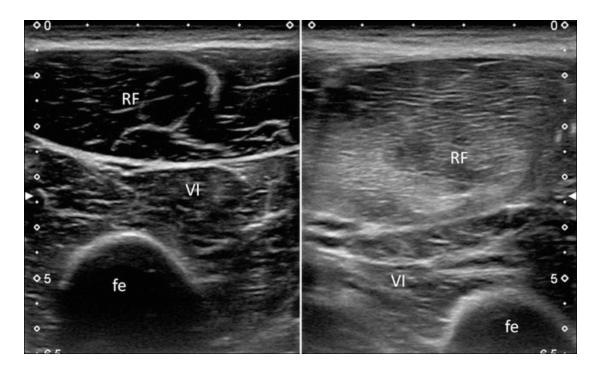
Transverse ultrasound image at the mid third of the anterior thigh shows moderate diffuse hyperechoic signal within the left rectus femoris muscle (>50 % of muscle surface area). The normal right rectus femoris muscle is shown for comparison. *RF* rectus femoris, *VI* vastus intermedius, *fe* femur
